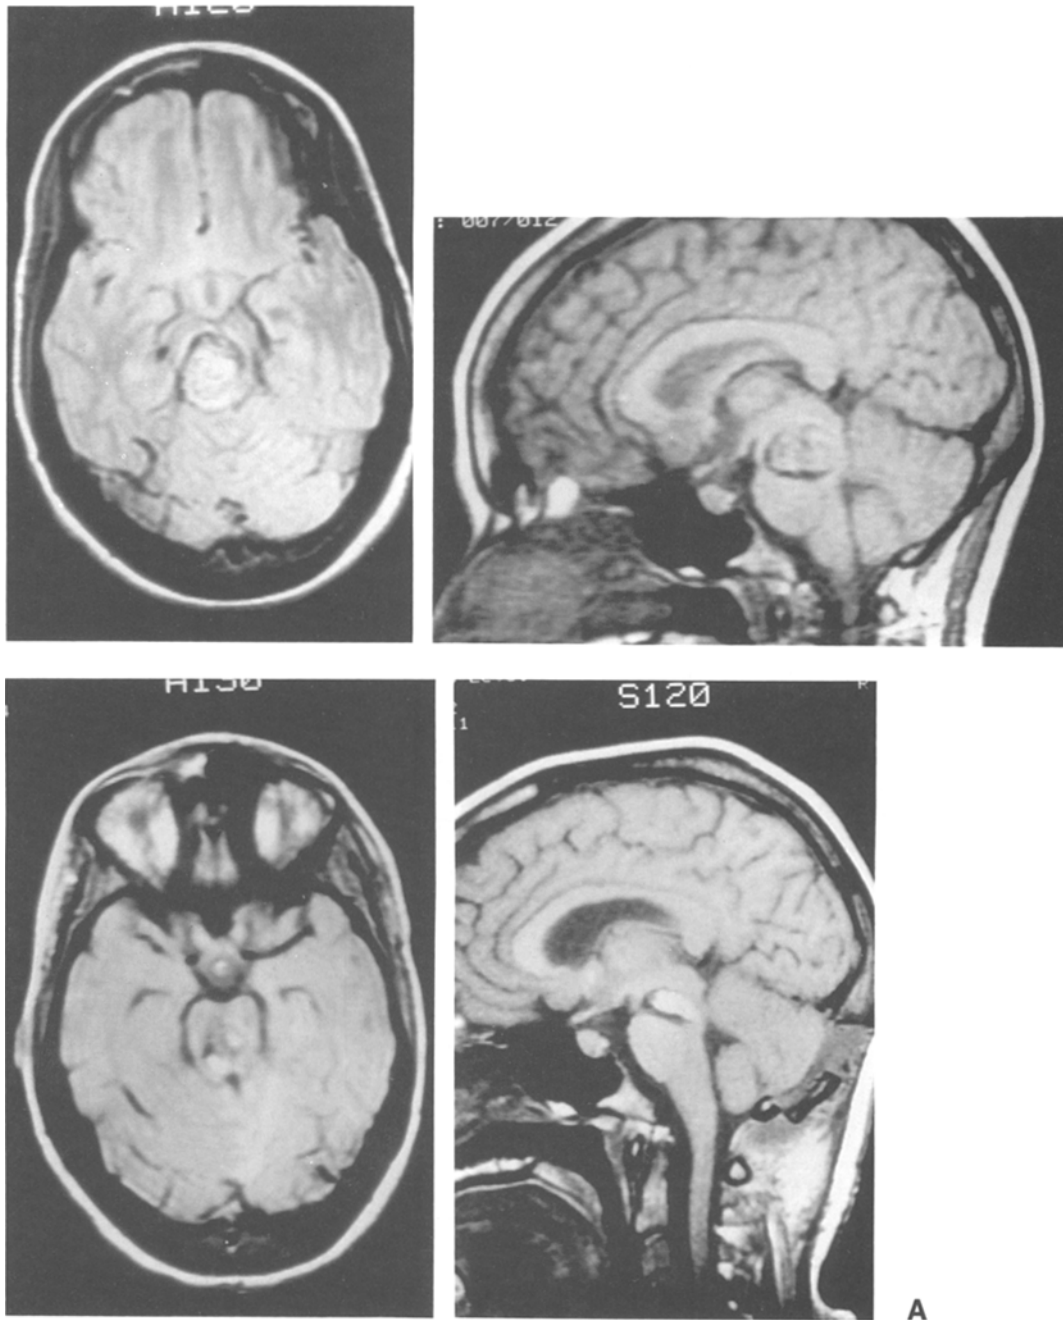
Magnetic resonance imaging provides definitive diagnostic information regarding cavernous angiomas. T<sub>1</sub> weighted (TR 500/TE 20 msec) technique shows a non-homogenous spherical lesion with mixed signal intensity representative of haemorrhage of various ages. There is a surrounding zone of low signal representing hemosiderin. Preoperative and postoperative images are shown of a mesencephalic (A) and ventral pontine (B) malformation
